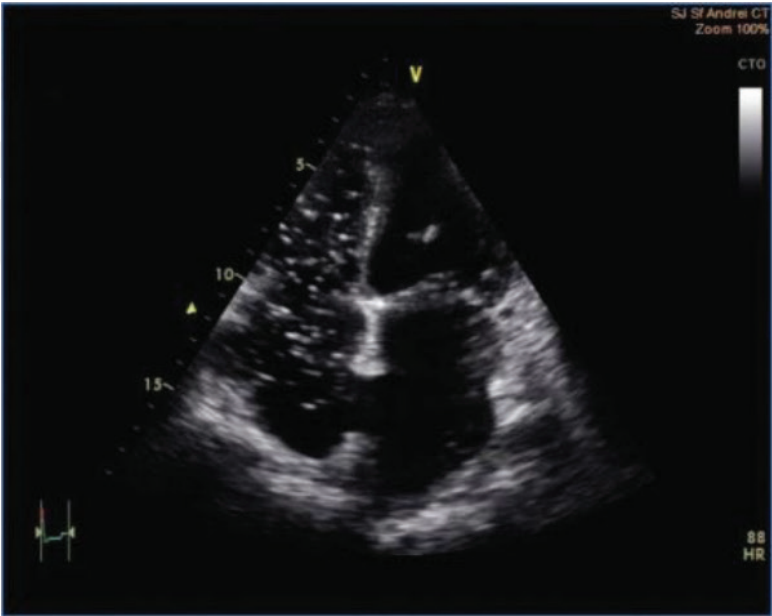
Contrast-enhanced echocardiogram. Apical four-chamber view after contrast injection (agitated saline) showing the presence of bubbles in the right chambers and no bubbles in the left chambers after the first systola.
